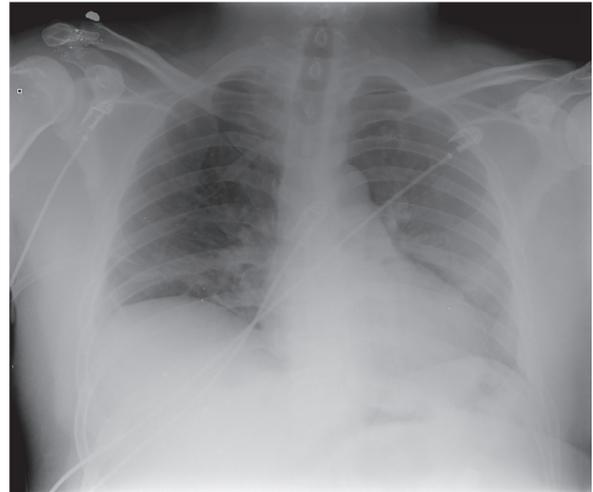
Chest radiograph demonstrating no acute pulmonary abnormalities.
